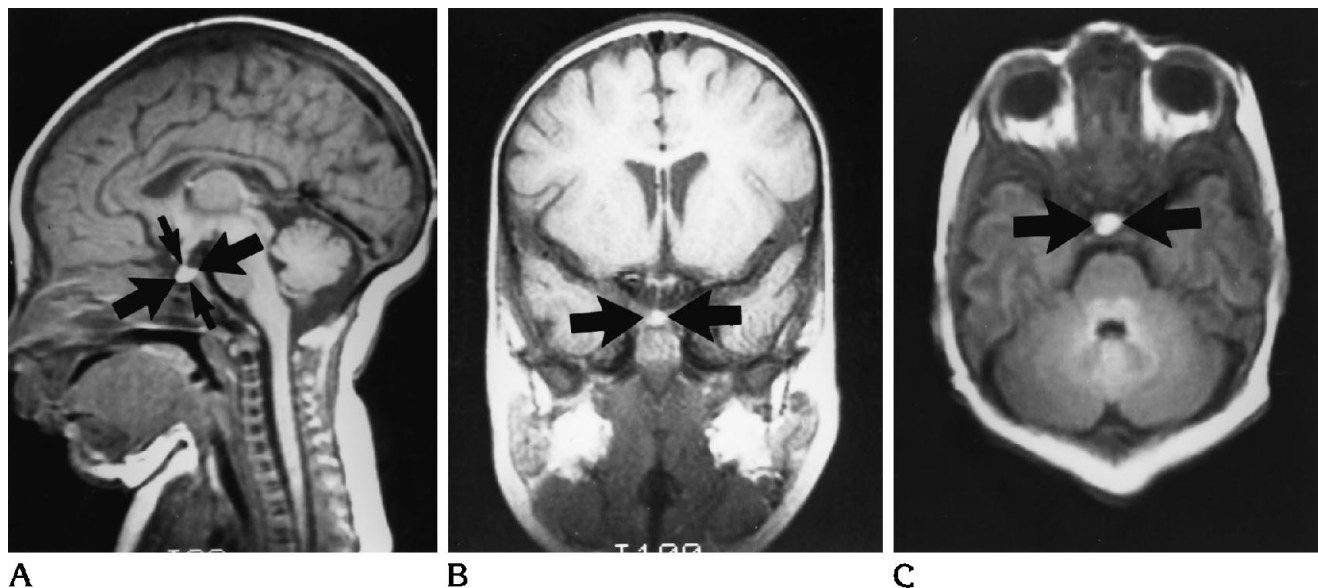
A, Sagittal (600/20); B, coronal (600/20); and C, axial (1500/700/30) MR images.
